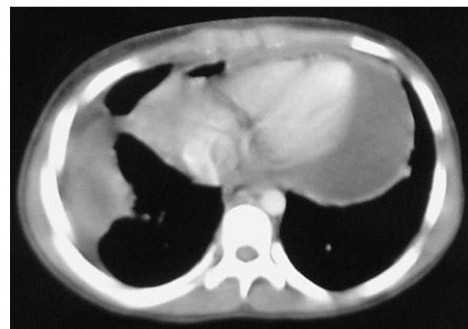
Chest CT scan demonstrating complicated pleural disease caused by TB. A pericardial effusion is also visible.
